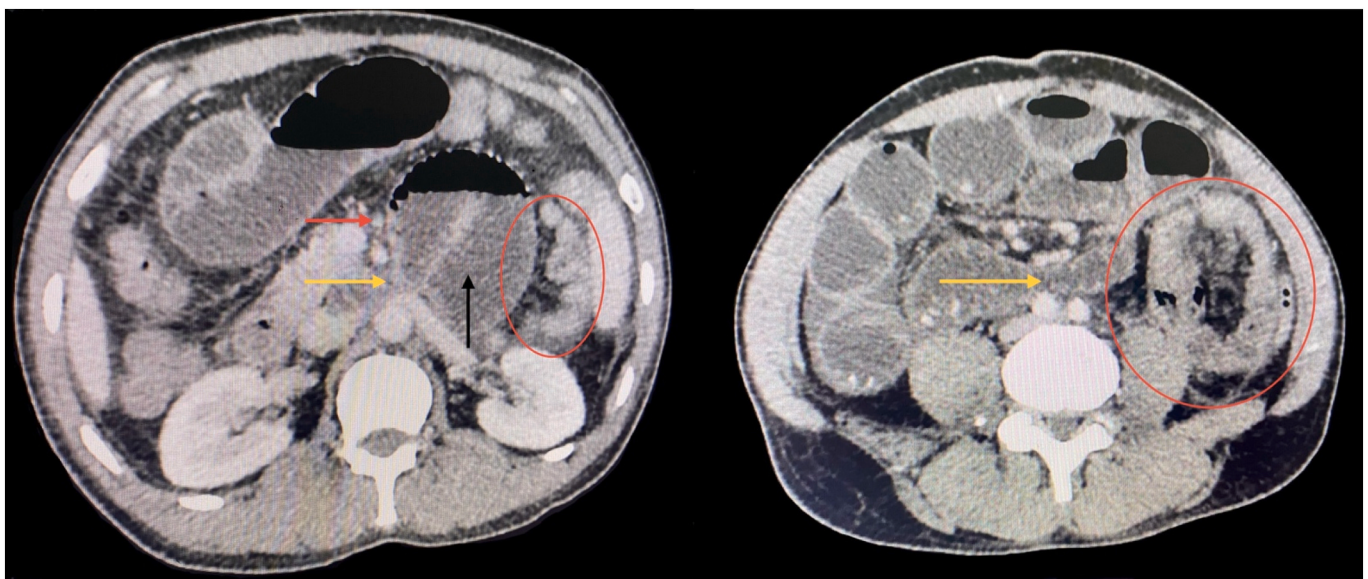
CECT axial section showing red arrow indicates the inferior mesenteric vein lying anteromedial to hernial sac. Yellow arrow showing herniated bowel loops through the foramen of Landzert with dilated small bowel loops indicated by the black arrow. The red circle encloses the cluster of herniated small bowel loops in the left upper quadrant resembling encapsulation or sac-like appearance- characteristic of left paraduodenal hernia. CECT: Contrast-Enhanced Computed Tomography.
